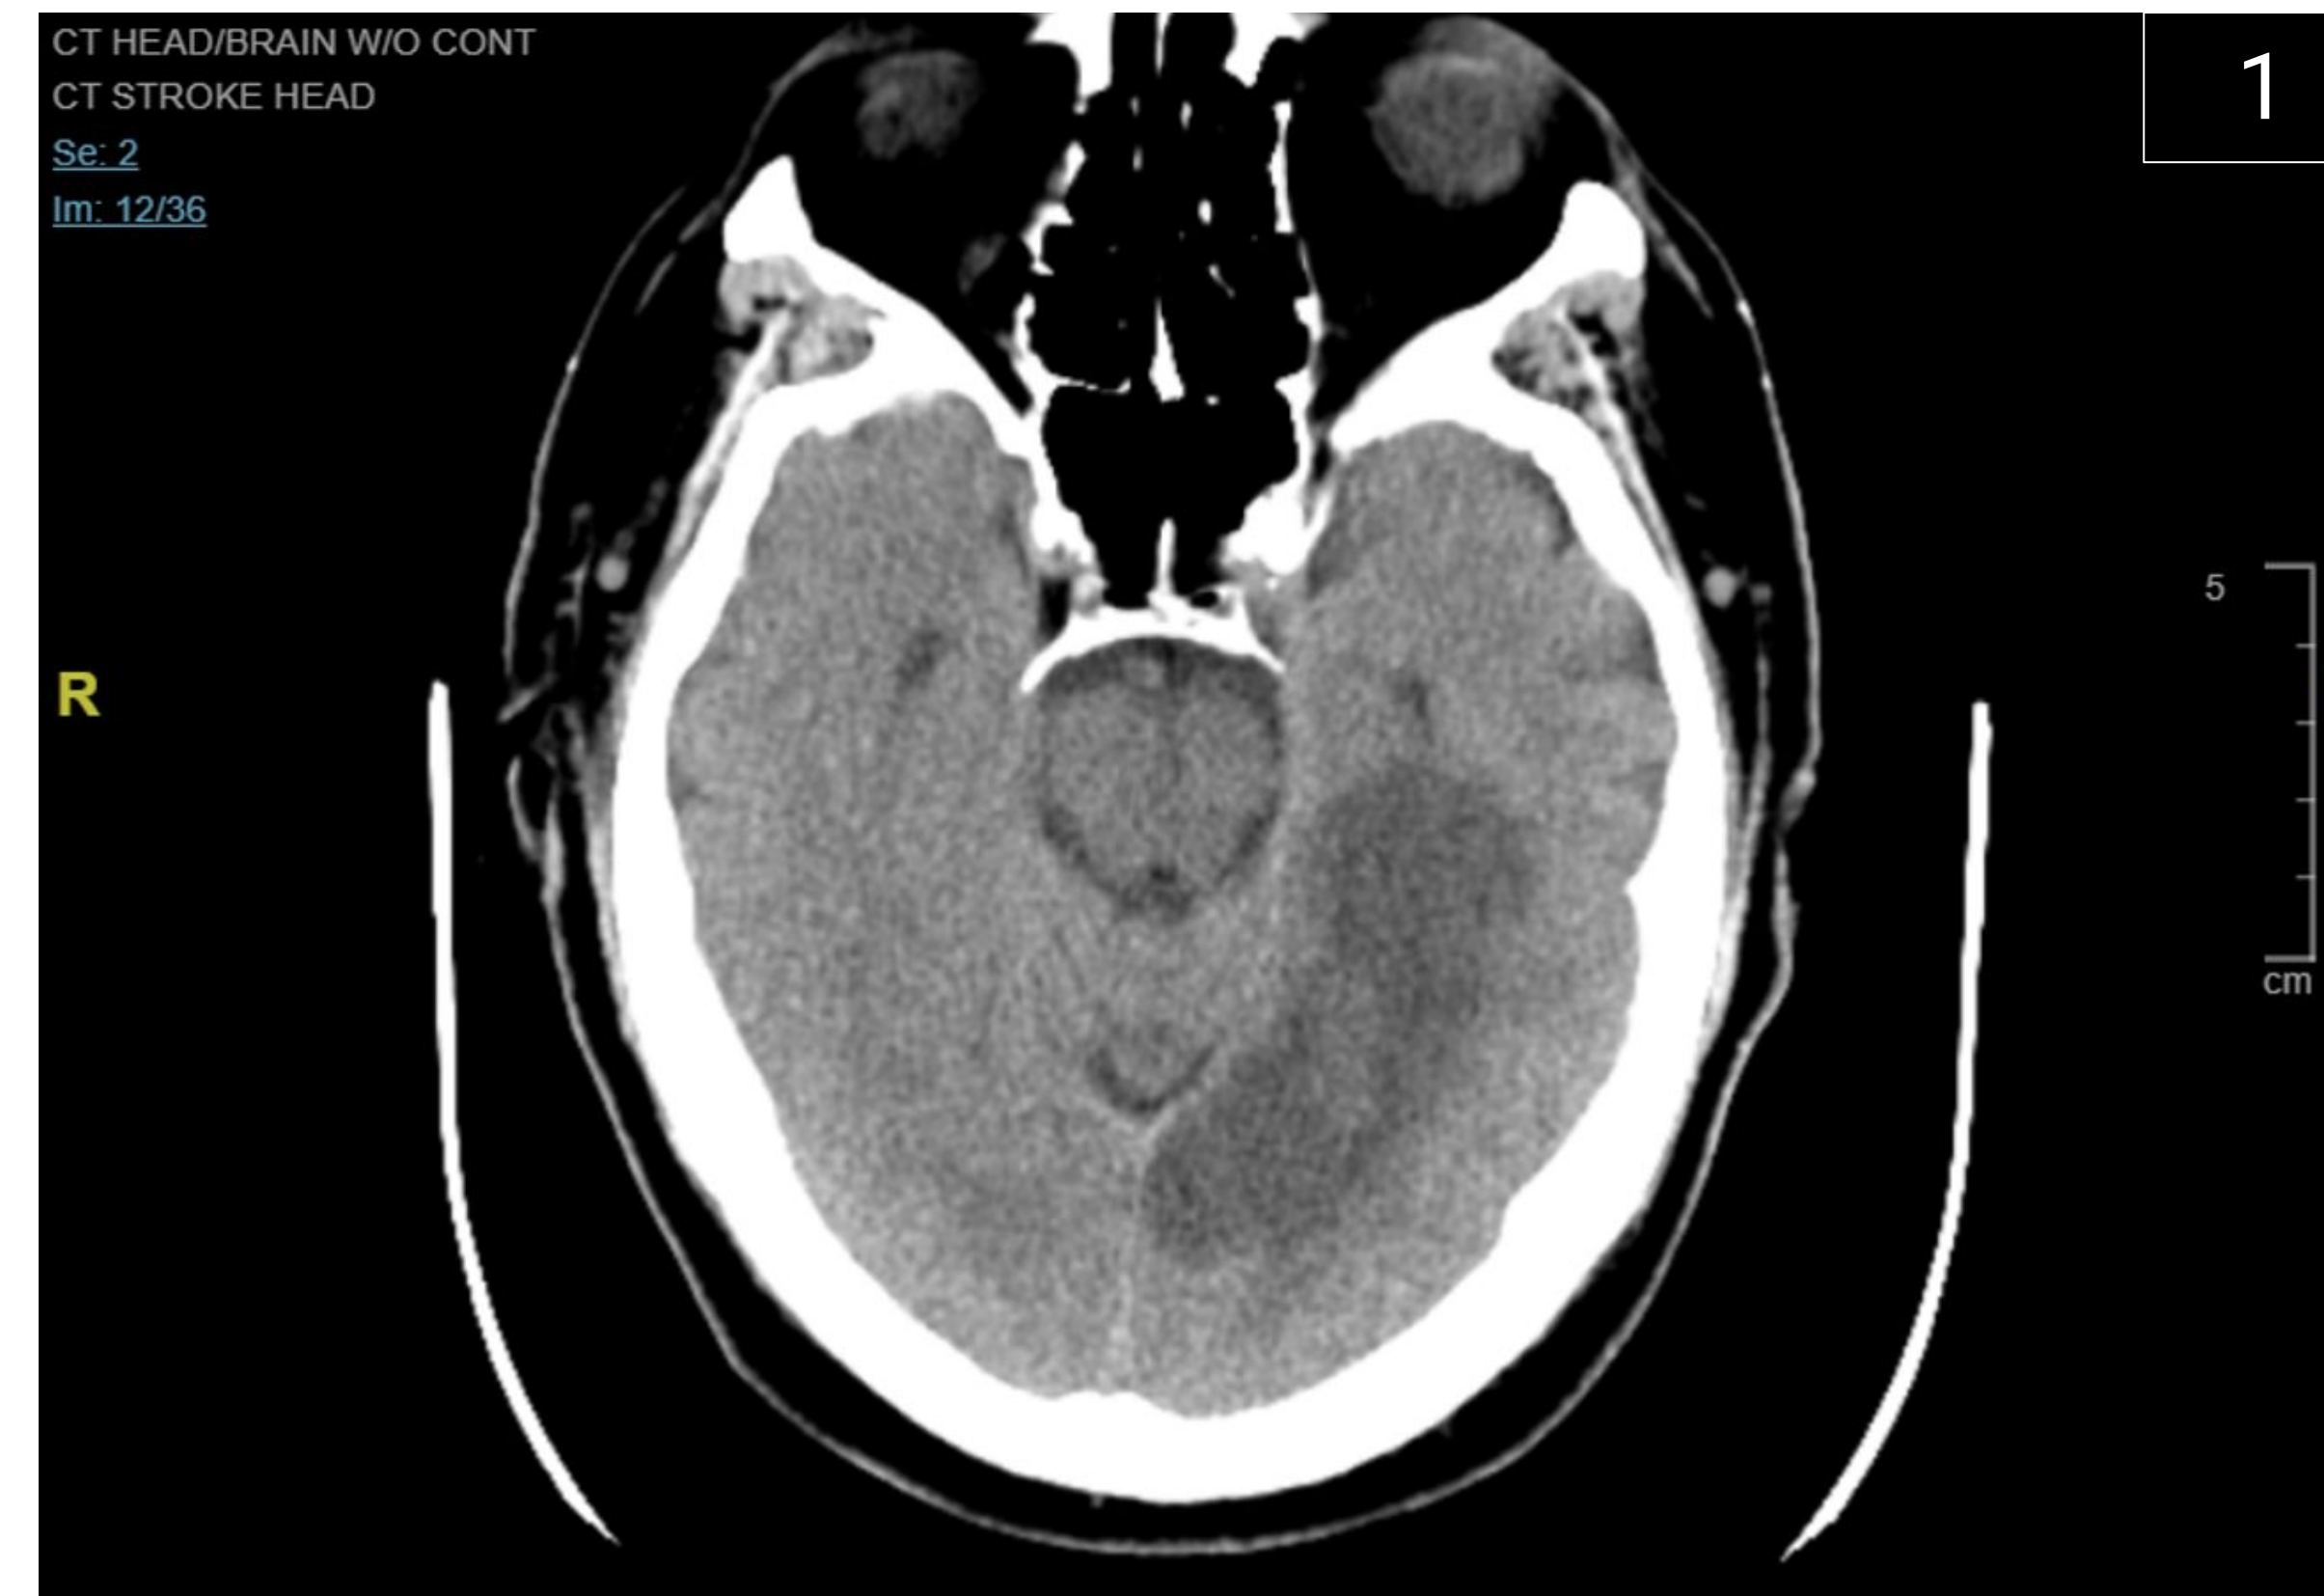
Patient's initial CT without contrast showing a hypodensity in the occipital and mesial temporal lobes, confirming a left PCA infarct without hemorrhagic transformation.
